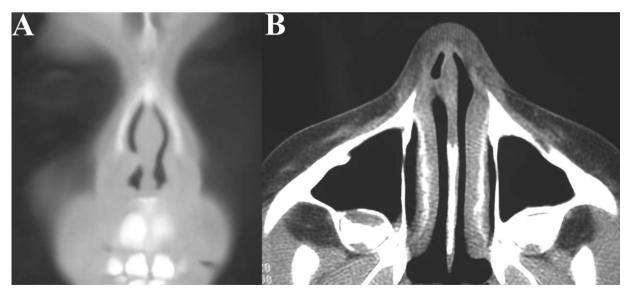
(A) Coronal and (B) axial CT scans demonstrating an isolated soft tissue synechia within the right nasal vestibule causing a vestibular stenosis.
